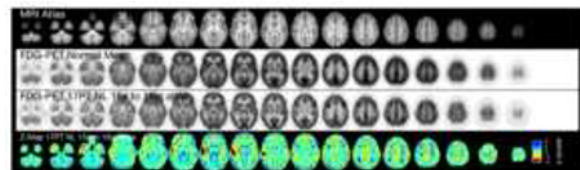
FDG PET data for a 15 year-old epilepsy patient in 16 year atlas space. Patient FDG PET data is hypometabolic in the region of the right temporal lobe compared to the normative atlas. The radiologist's report notes hypometabolism in the right anterolateral temporal lobe and right perisylvian region.
